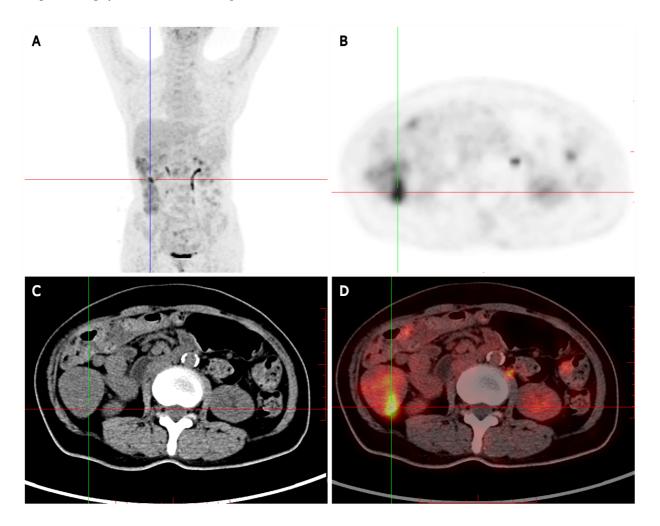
Positron-emission tomography/computed tomography showing multiple nodules with increased fluorodeoxyglucose uptake in the stomach wall, descending duodenum, and bulb, in the small intestine (obvious increase in the ileum), and the colon (obvious increase in the ascending colon). Multiple nodular thickening with increased fluorodeoxyglucose (FDG) uptake was observed in the proximal rectum. A: Wholebody maximum intensity projection 18F-FDG and positron-emission tomography (PET) image; B: PET; C: Computed tomography (CT); D: PET/CT.
